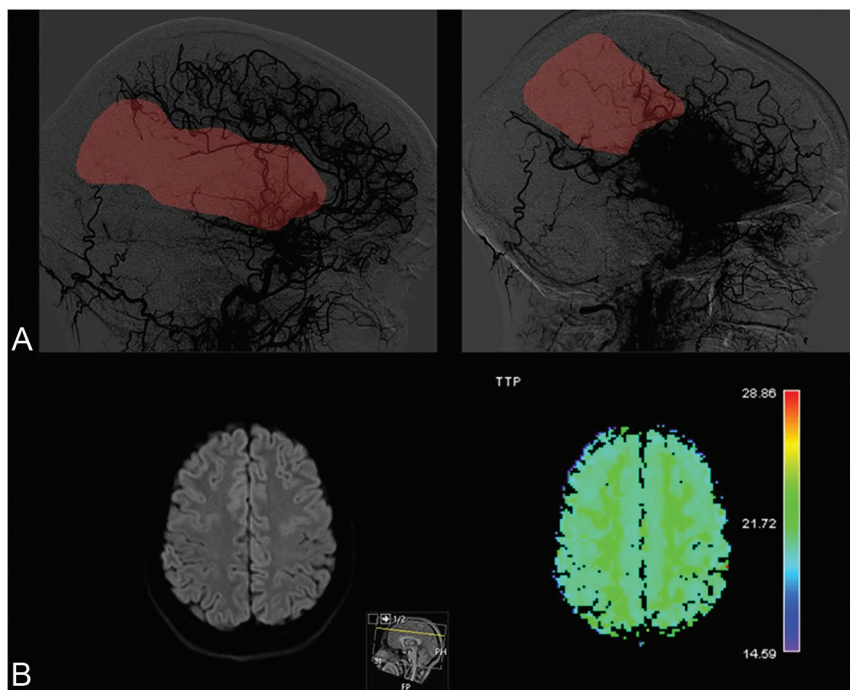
Patients with DR after IA urokinase. *A*, The first DSA shows right-sided occlusions of the M1 MCA segment (*left panel*). The last DSA after MT shows that the patient has achieved reperfusion in 50% of the initial target territory (eTICI 2b50) (*right panel*). DSA runs are shown with high contrast in order to emphasize the capillary phase deficits. Areas in red show nonreperfused territory. *B*, Follow-up MR imaging performed 24 hours after the end of the intervention. DWI shows no signs of a new infarct despite incomplete reperfusion on the final DSA series (*left panel*). Postprocessed perfusion imaging shows DR with no residual perfusion deficit (*right panel*).
